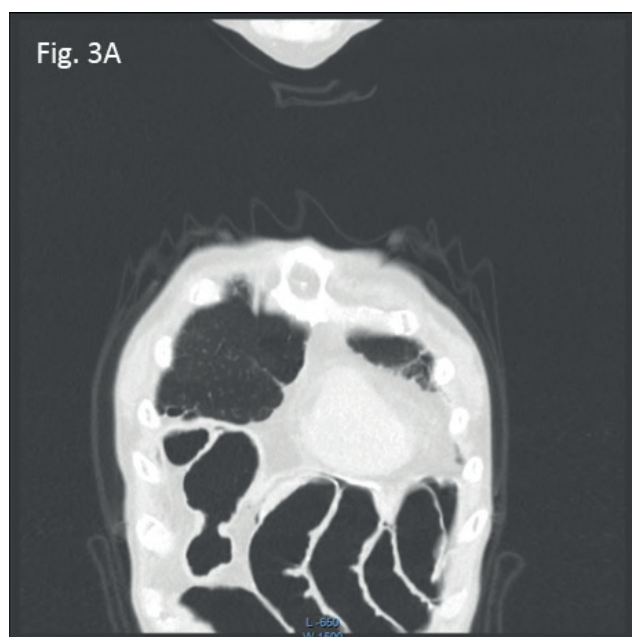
Abdominal CT scan reveals the improvement of pneumoperitoneum, dilated intestinal canals, and air-filled cysts of the walls.
